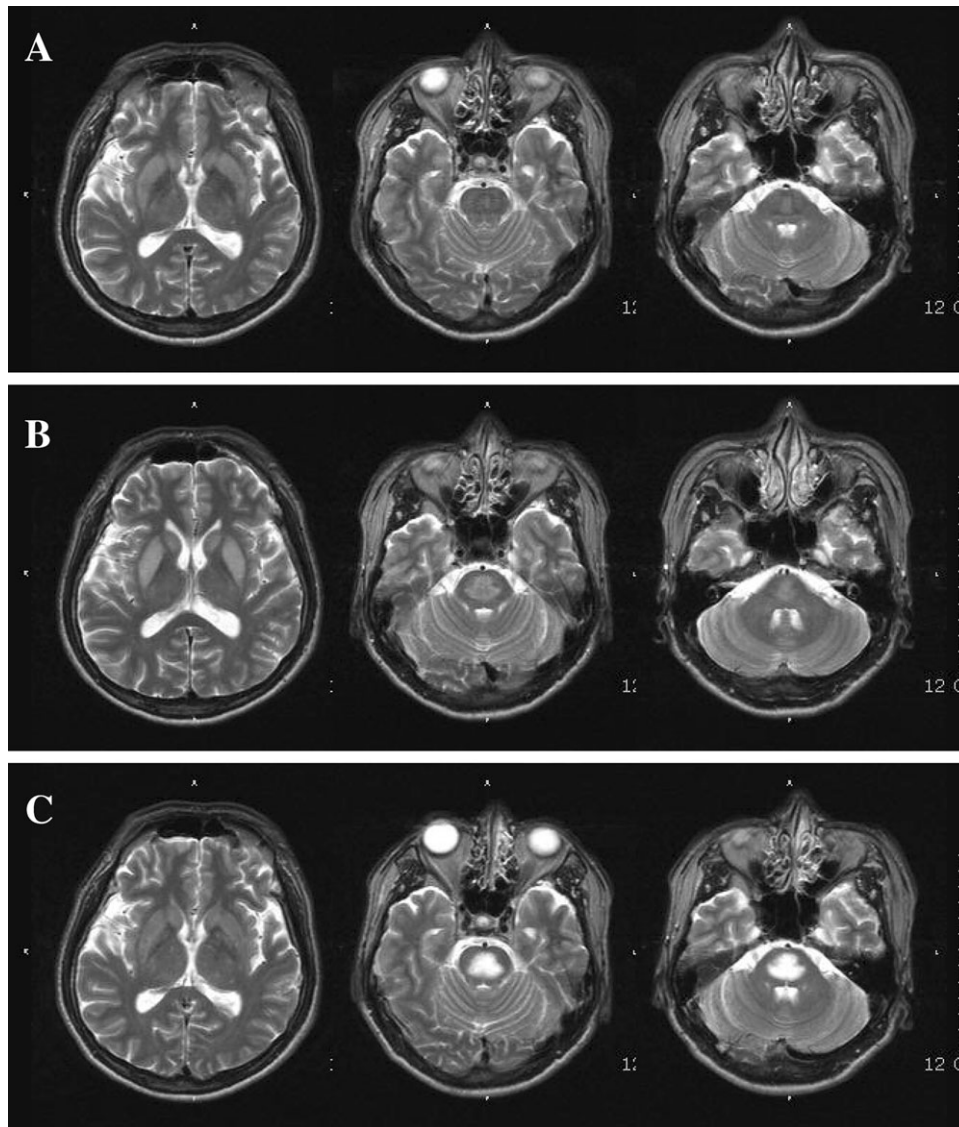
T2 weighted axial MRI of the patient. On the initial MRI (A), there are hyperintensities involving the bilateral basal ganglia and pons. The MRI (B) performed 5 days after the development of psychiatric symptoms showed extension of the previous lesions. The MRI taken after 1 month (C) revealed no recovery or resolution.
